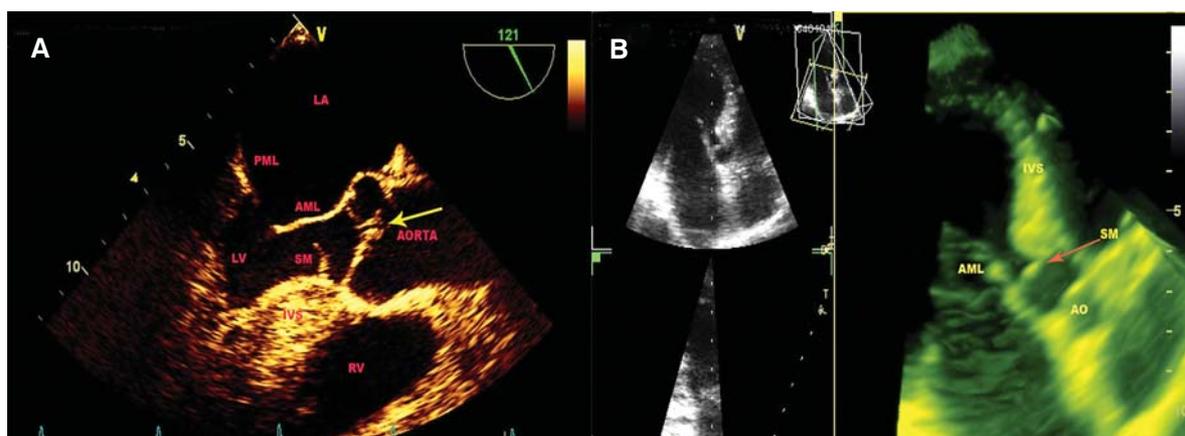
A. Aorta, long-axis, mid-oesophageal view shows a mobile, thin, fibrous membrane (SM) within the left ventricular outflow tract which is attached to the basal anterior septum. The yellow arrow indicates the incomplete diastolic coaptation of the aortic cusps. B. three-dimensional echocardiography showing the sub-aortic membrane (pink arrow, SM) in the left ventricular outflow tract. AML – anterior mitral leaflet AO – aorta; IVS – interventricular septum; LA – left atrium; LV – left ventricle; PML – posterior mitral leaflet; RV – right ventricle.
